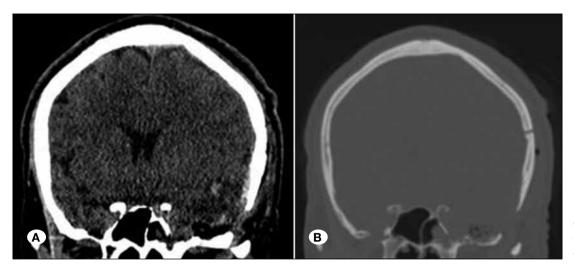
Cranial coronal CT scans (A and B) one day after operation.
